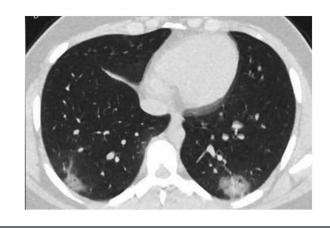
An axial nonenhanced chest CT image showed rounded GGOs in the peripheral regions of the lower lobes.
